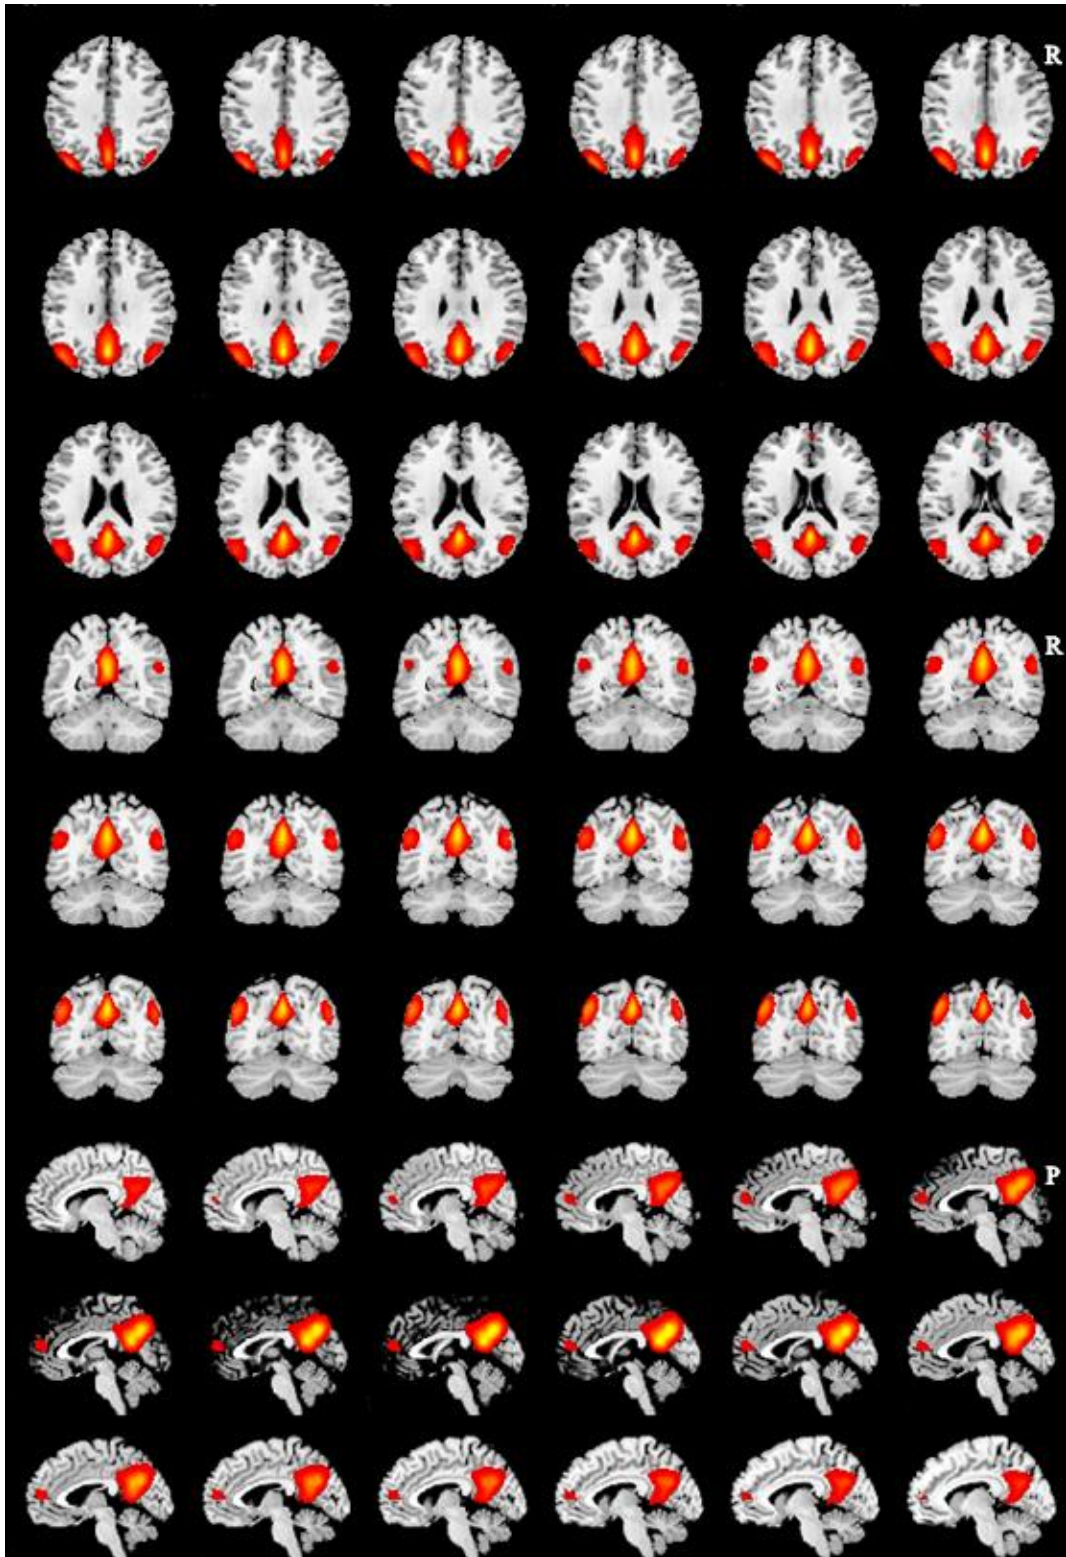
Study participants' average ICA component that best matched the healthy DMN template. The image displayed is a z statistic map of the default mode network (DMN) registered on a template T1-weighted anatomical image. The upper panel shows selected axial images, the middle and the bottom panels demonstrate images in coronal and sagittal planes, respectively. The DMN overlay is thresholded at $z > 2.3$. R = Right and P = Posterior.
